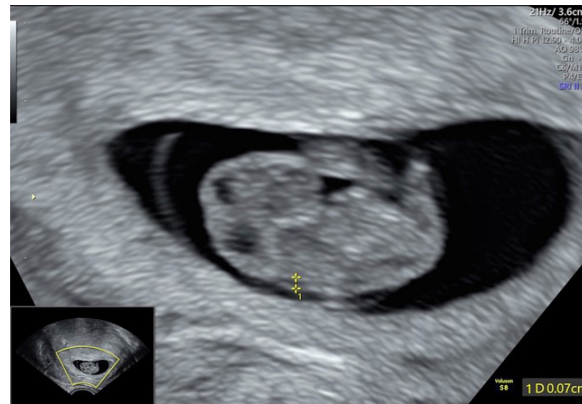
Fetal ultrasound image demonstrating nuchal translucency at 8w^{+0d} of gestation.
